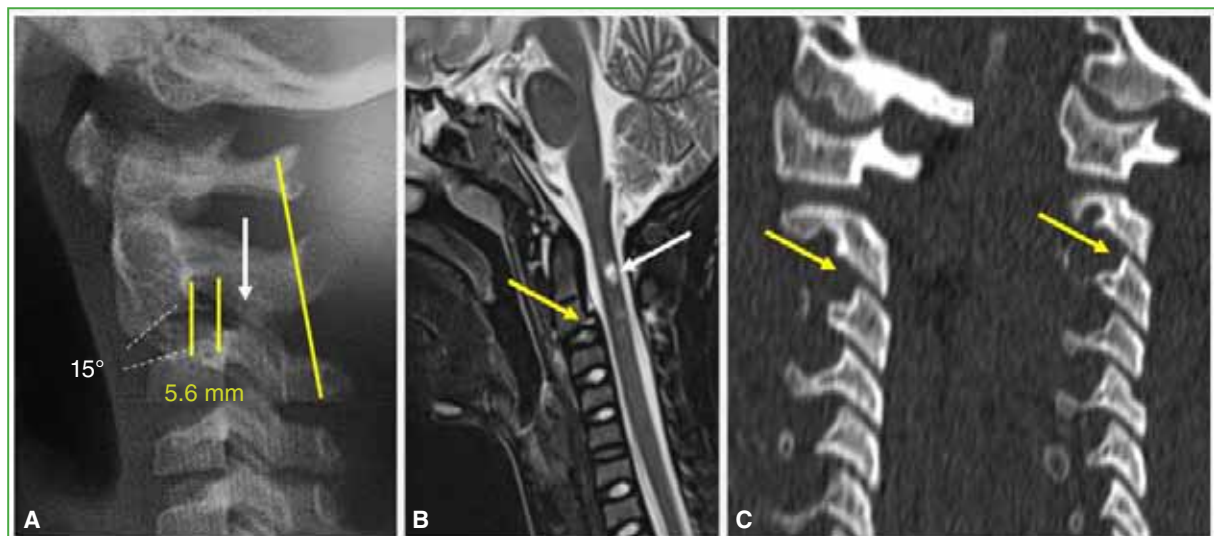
Eight-year-old boy involved in a frontal-impact car accident, presenting with pneumothorax, elevated intracranial pressure (eICP), and requiring mechanical ventilation for three days. The patient exhibited central cord syndrome and flaccid diparesis of the upper limbs with a C4-C5 level injury. Imaging studies of the cervical spine. A. Cervical spine radiograph: kyphosis of 15 degrees, sagittal displacement of 5.6 mm (vertical yellow lines) and normal SL tracing. B. MRI: Salter-Harris I epiphysiolyis of the axis (yellow arrow), with pre- and intervertebral fluid signal and intramedullary fluid signal. C. CT: sagittal paramedian sections showing subluxation of both C2-C3 facet joints.
